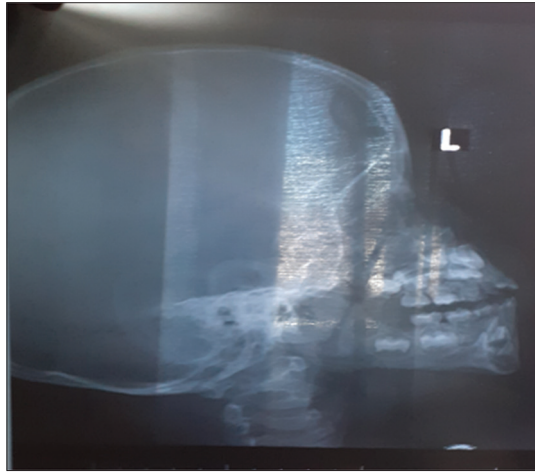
Pre-operative X-ray of the nasopharynx lateral view showing obstructive adenoid
